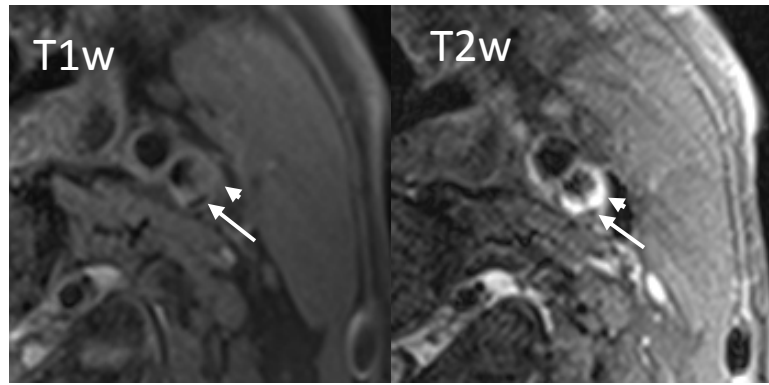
Atherosclerotic plaque imaged by black-blood magnetic resonance angiography: T1-weighted (T1w) and T2-weighted (T2w) imaging. Different plaque components including calcification (arrows) and loose matrix (arrow heads) are clearly shown, as well as the interface of vessel wall and lumen.
